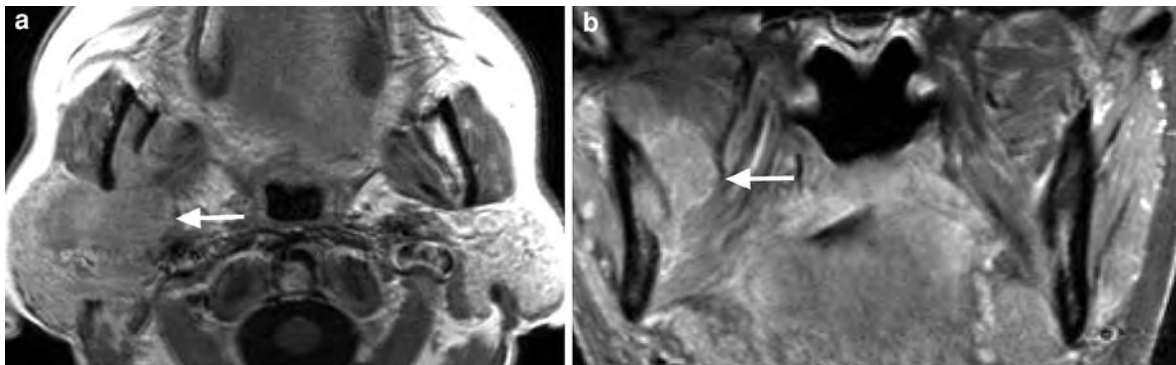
Malignant intrinsic lesion of the right masticator space in a 72-year-old male with numbness and pain of the right V3 territory with biopsy-proven multiple myeloma. a Axial T1-weighted MR image after i.v. contrast material shows a mass (arrow) infiltrating the right mandible and the adjacent
